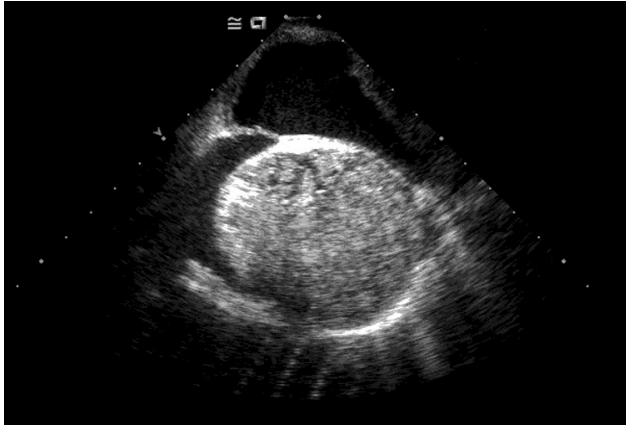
Transesophageal echocardiogram demonstrating a 6.0 × 5.0 × 3.1 cm hemangioma arising from the right atrium and involving the left atrium and atrial septum.
